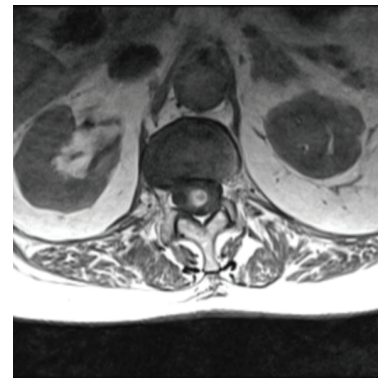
Cone Cavernome Hemorrhage at Axial Spine T1 MRI.
